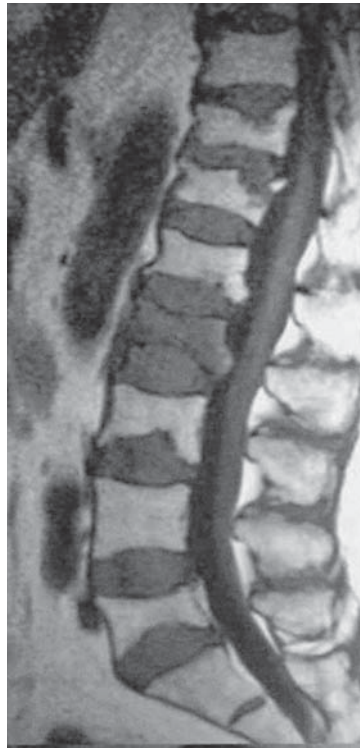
This 70-year-old woman with primary osteoporosis presented with severe focal back pain and urinary retention. (A) Lateral spine radiograph demonstrates a mild compression deformity at L2. (B) CT sagittal reconstruction shows a compression fracture at L2 with fracture lines extending through the posterior wall and inferior endplate. (C) Sagittal T1-weighted and (D) STIR MR images show edema signal in the L2 vertebral body, consistent with acute fracture. Note retropulsion of the superior endplate of L2. Remaining vertebral bodies show normal signal on MRI.
